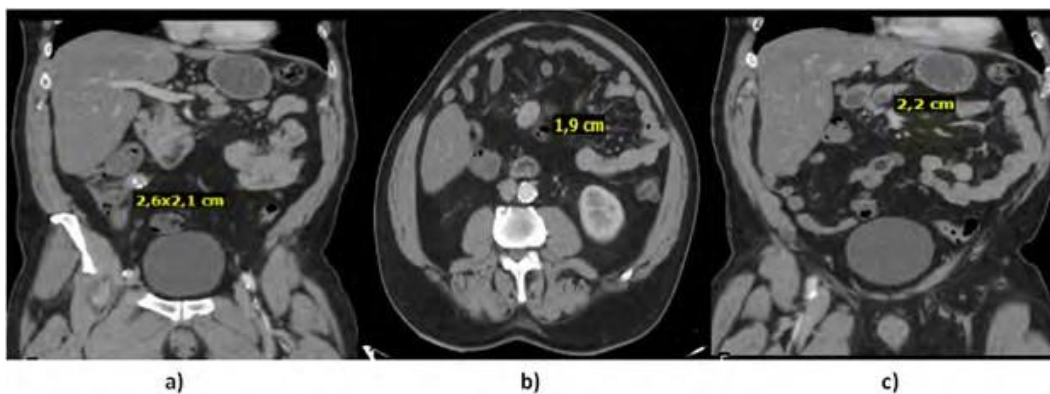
Abdominal-pelvic CT scan. a) Tumor in the right lower quadrant with calcifications, b) Tumor in the root of the mesentery, next to the mesenteric vessels, c) pancreas with cystic image of 2.2 cm.
